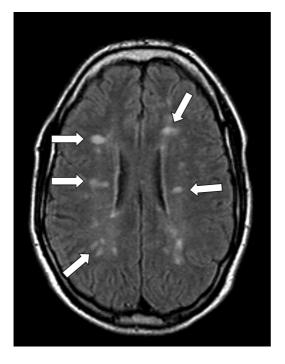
MRI showing multiple periventricular white matter lesions, consistent with multiple sclerosis.
